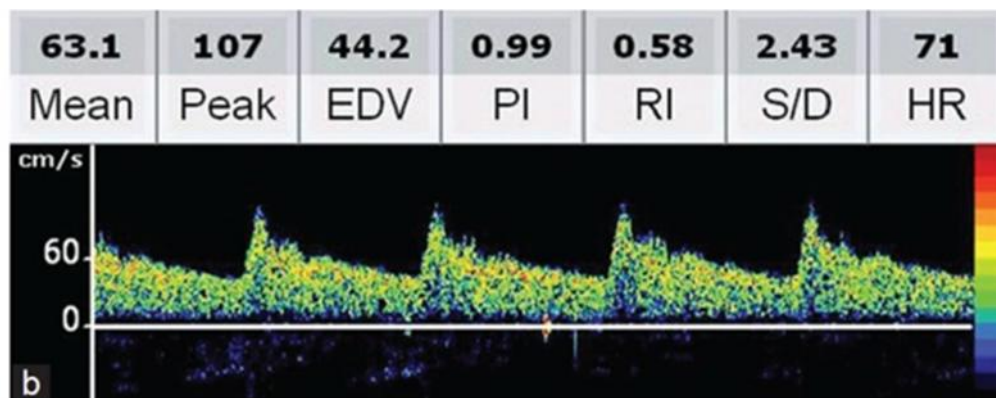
Transcranial Doppler waveform
